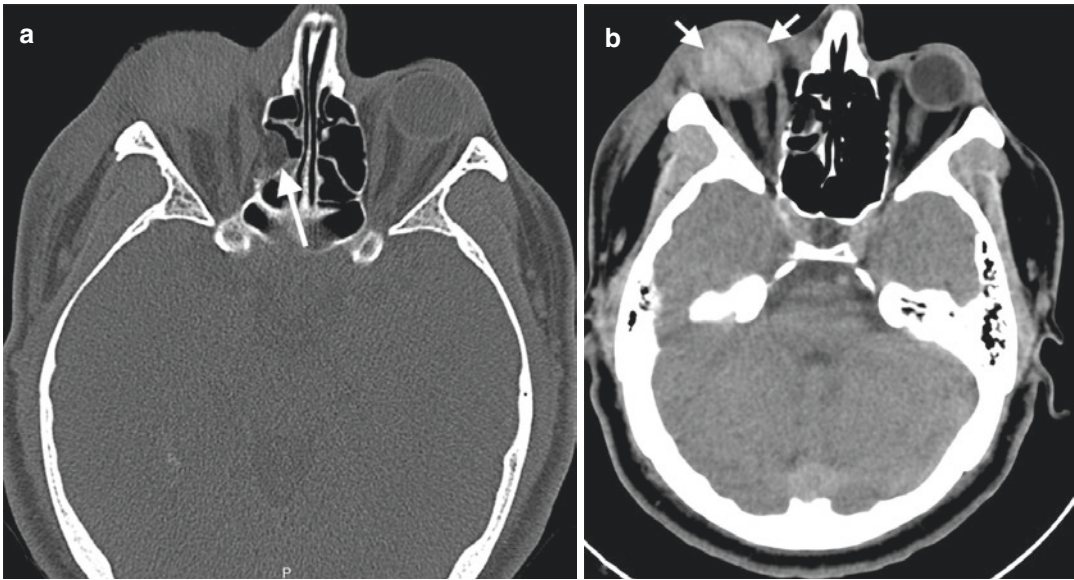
Blow-out fracture with globe hemorrhage in a 42-year-old man with a history of MVA. (a) Axial CT image on bone window shows blow-out fracture of right
